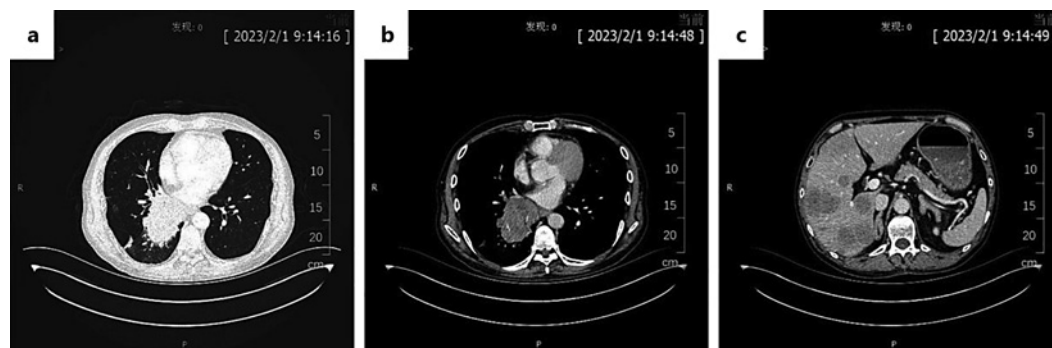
a, b Contrast-enhanced chest CT showed soft tissue foci in the right hilar-inferior lobe and enlarged lymph nodes in the mediastinum, distal obstructive pneumonia, and right-sided pleural effusion. c Abdominal CT showed multiple liver metastases, bilateral adrenal metastases, and a normal pancreas.
